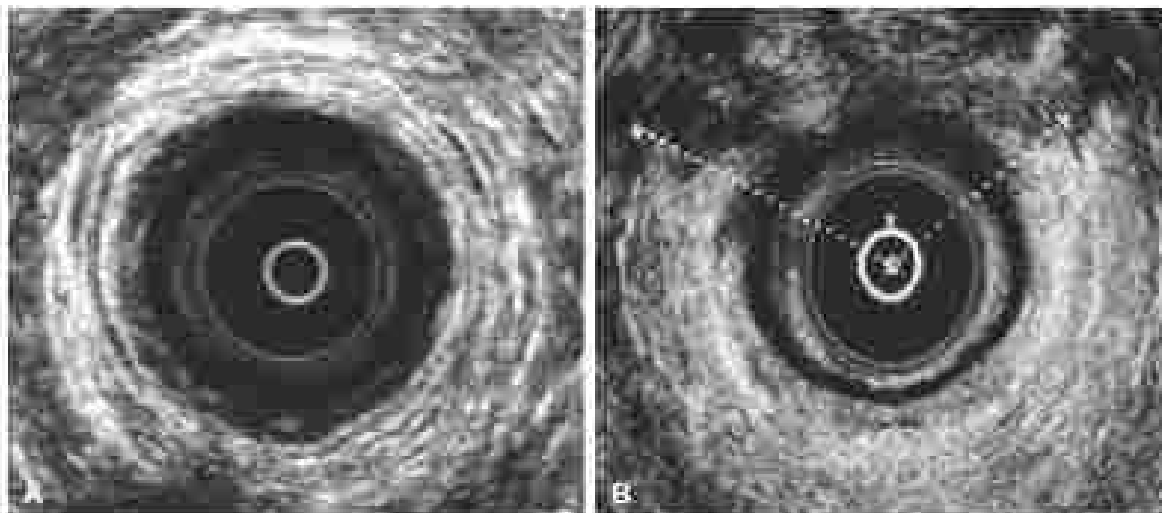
Endoanal ultrasound imaging of the anal sphincter muscle. (A) Most circumferential sphincter complex. (B) Approximately 180-degree anterior sphincter defect.
